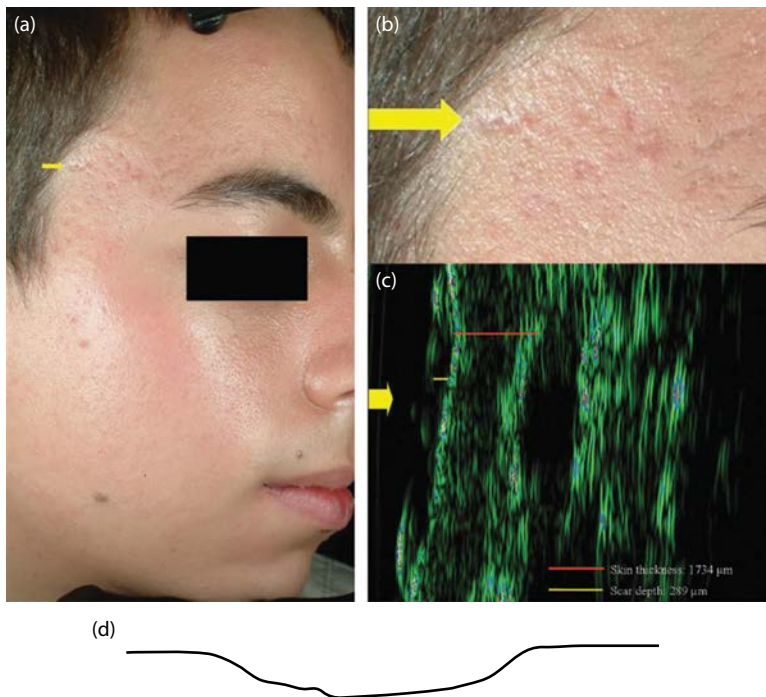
Rolling scar: (a,b) clinical and (c) ultrasound appearance; (d) cross-sectional profile.
